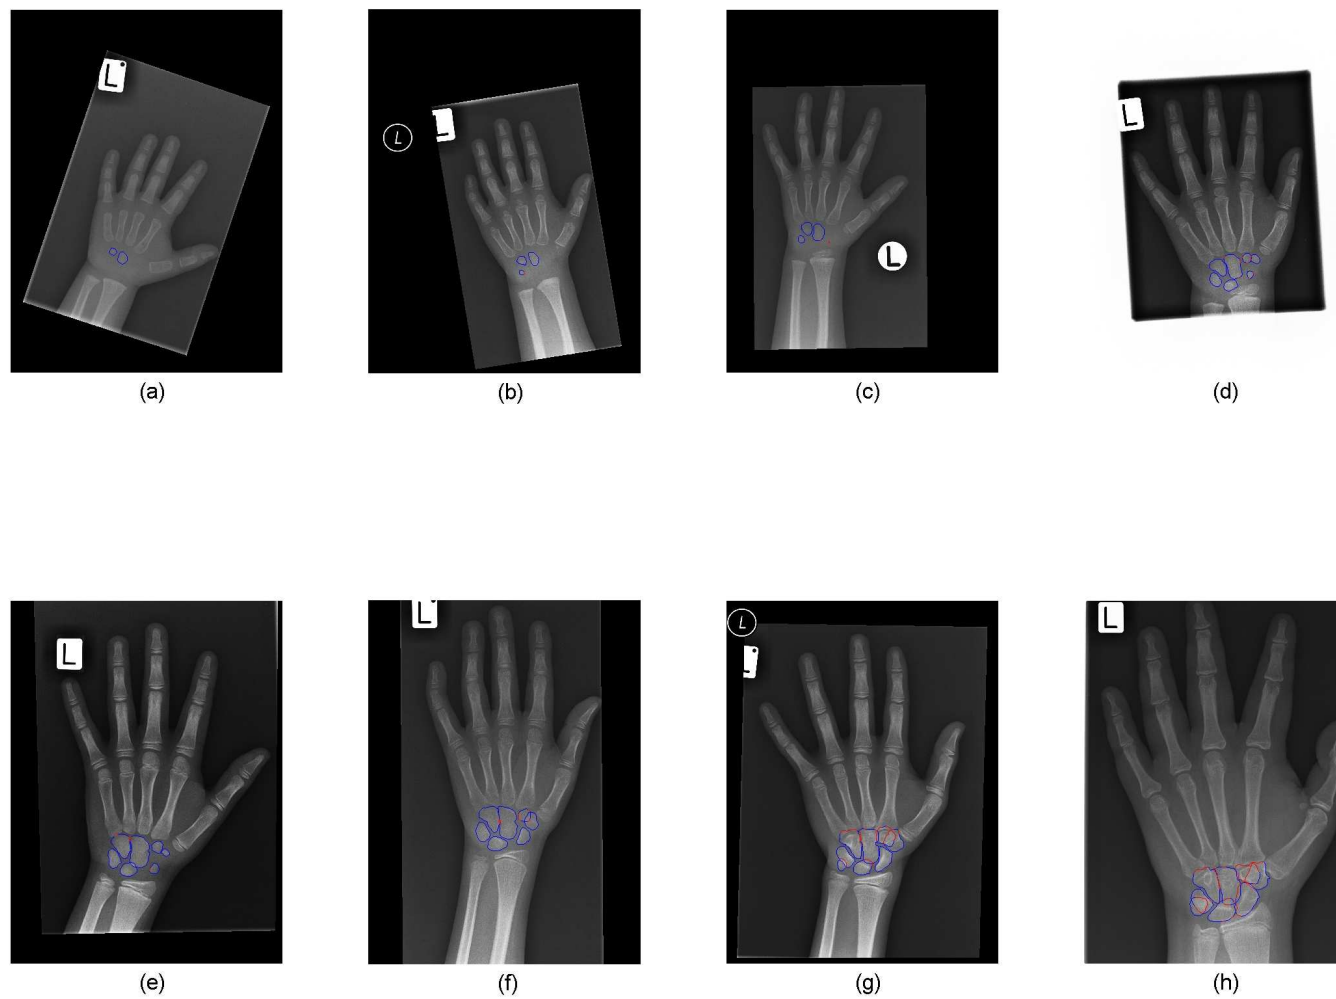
The eight hand-wrist radiographs used as the development dataset for both denoising and carpal bone segmentation. The original radiographs are shown with contours marked by a radiologist. The contours were colour-coded according to the confidence the radiologist had in the bone edge - blue was high confidence; red was low confidence. (a)–(d) non-overlapping carpal bones; (e)–(h) overlapping carpal bones.
